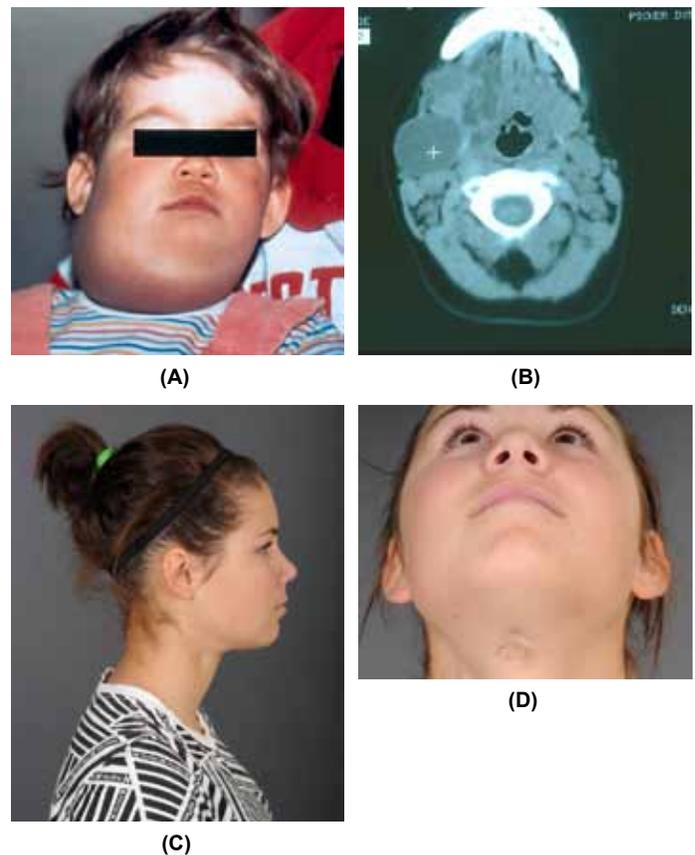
Unilateral suprahyoid, mixed macro- and microcytic: (A) At age 2 years, inflammatory response postsclerotherapy with Ethibloc. (B) CT scan at age 2 years; note microcystic infiltrating lesions anterior to large cyst. (C) 13 years follow-up after two sclerotherapies with Ethibloc and one infection at age 2 years. (D) Residual submental scar from Ethibloc extrusion.
